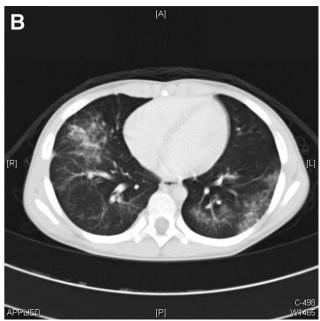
Evidence of pulmonary hemorrhage. A, Chest radiograph showing bilateral diffuse consolidation; B, Chest CT scan showing multiple ground-glass opacities.
